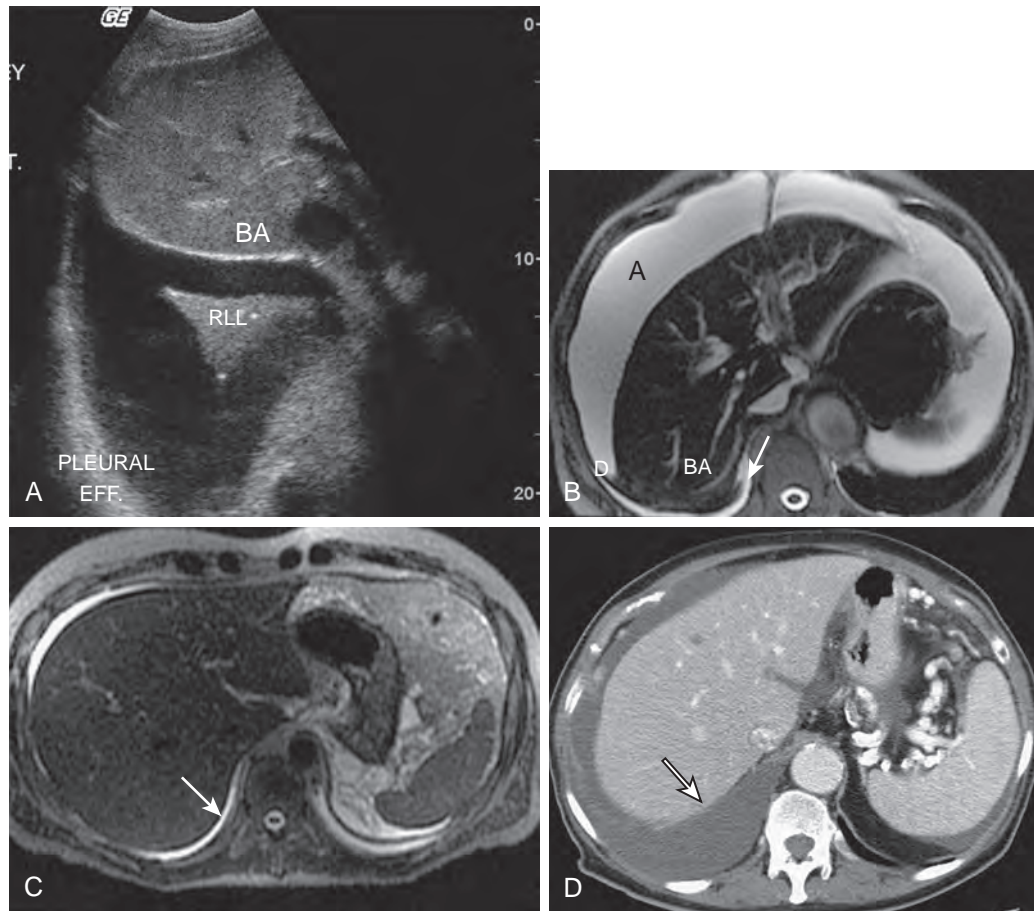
Differentiating ascites from pleural fluid. A. The bare area (BA) sign is demonstrated on this transverse sonogram, which shows pleural fluid posterior to the bare area of the liver. Ascites would not be present in this area because it is excluded from the peritoneum. *RLL*, Right lower lobe of lung. B. Diaphragm sign. An axial MR scan shows high signal intensity pleural fluid (arrow) outside the diaphragm (D) posterior to the bare area (BA) of the liver. *A*, Intraperitoneal fluid. C. Displaced crus sign. An axial MR image shows a sliver of high signal intensity fluid (arrow) separating the spine from the left hemidiaphragm. D. Interface sign. The interface between pleural fluid and liver (arrow) is less distinct than that between ascites and liver.
